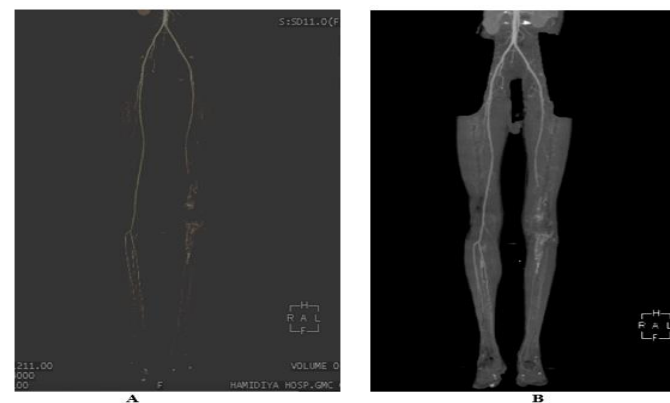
57 years old smoker, non-hypertensive patient, came with left thigh & leg pain & dry gangrene CT angiogram with VRT & MIP images showing filling
